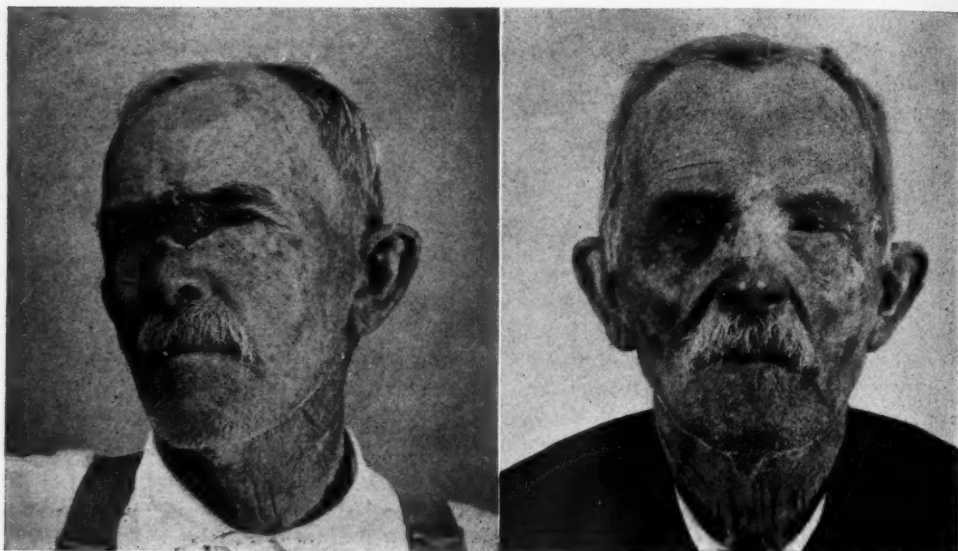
Farmer, age 67. Was first seen September 12, 1921. Family history negative. The growth began fifteen years before in inner corner of left eye. When treatment was begun (Fig. 1A, left) ulcer covered entire bridge of nose between eyes. Edges of ulcer were irregular, indurated and elevated. Clinical diagnosis was basal cell carcinoma. Treatment consisted of ten erythema doses of X-ray, given in five exposures. Lesion healed promptly and there was no evidence of recurrence January 1, 1924, the date of last report (Fig. 1B, right).
